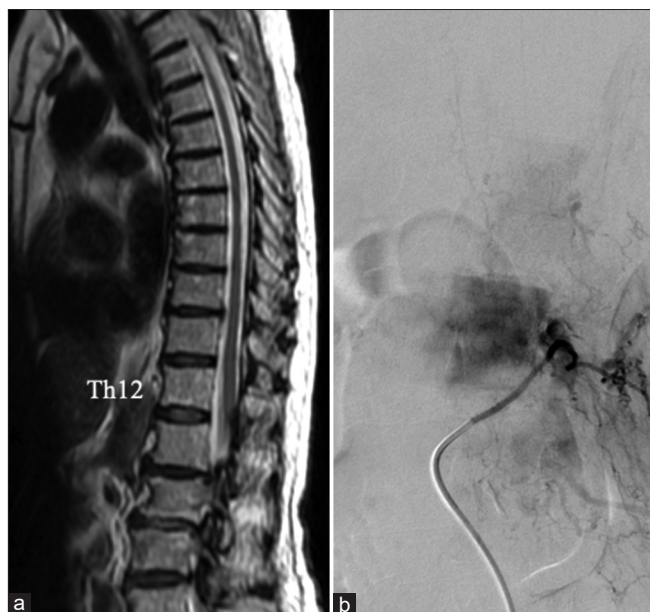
(a) The follow-up magnetic resonance imaging shows the disappearance of the spinal cord congestion. (b) The follow-up spinal angiography demonstrates no recurrence of the shunts and improved venous flow of the spinal cord.
